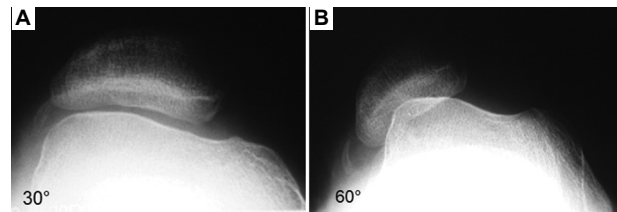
Radiographs of the right knee. Axial radiographs show (A) well-centered patella at 30° and (B) lateral patellar dislocation at 60°. Source of image by the author.
